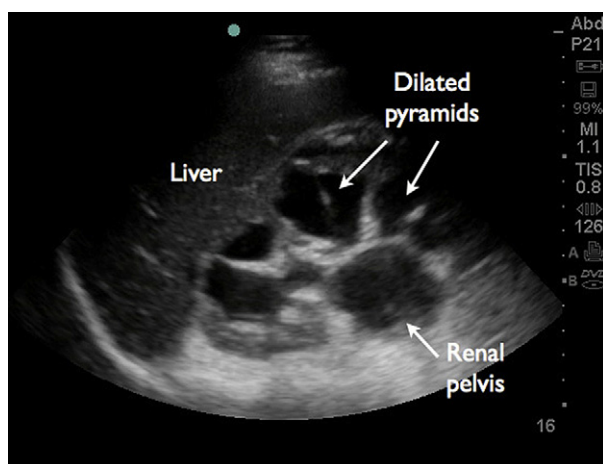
Longitudinal ultrasound image of patient’s right kidney with dilated medullary pyramids.
